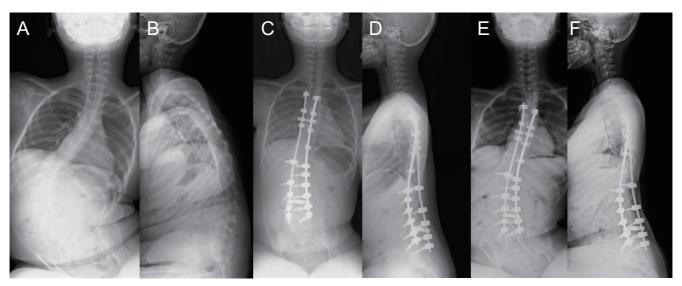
Radiographs of a 10-year-old girl with scoliosis secondary to spinal muscular atrophy. Preoperative frontal view (A) at 1 month postoperatively and (C) at the final follow-up (24 months postoperatively) (E); and preoperative lateral view (B) at 1 month postoperatively, (D) at the final follow-up (24 months postoperatively), and (F) in the sitting position. Cobb angles were 87° preoperatively, 28° at 1 month postoperatively, and 33° at the final follow-up. The correction rates of the Cobb angle were 67.8% at 1 month postoperatively and 62.1% at the final follow-up. Pelvic obliquity (PO) was 30° preoperatively, 11° at 1 month postoperatively, and 13° at the final follow-up. The correction rates of PO were 63.3% at 1 month postoperatively and 56.7% at the final follow-up.
